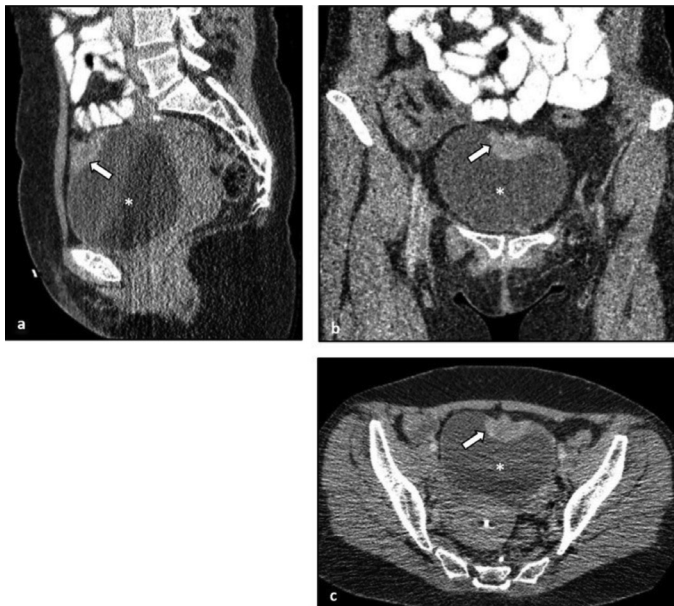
In sagittal (a), coronal (b), and axial (c) intravenous contrast-enhanced CT images, a soft tissue mass (arrows) measuring 20x40x40 mm with a slightly hypodense contrast-enhanced center is observed in the anterior dome of the bladder (*), located in the midline and not clearly distinguishable from the bladder walls, with a nodular extension toward the anterior perivesical fat
